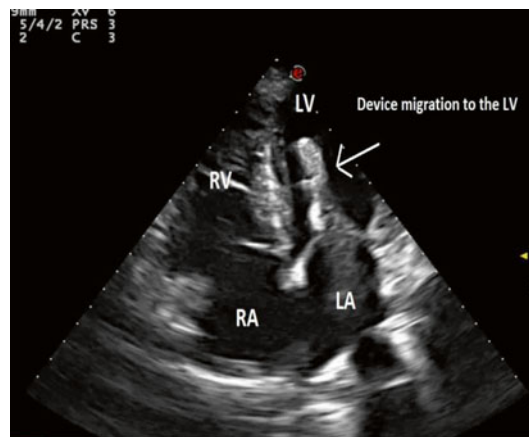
Transthoracic echocardiography in four-chamber view showing migration of the device into the left ventricle. RV right ventricle, RA right atrium, LV left ventricle, LA left atrium
